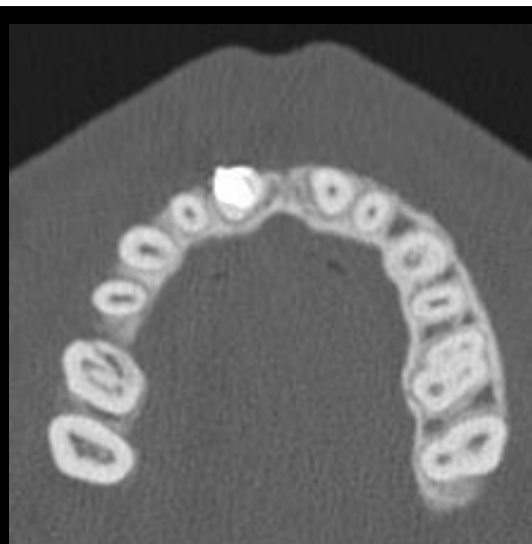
Axial CT Maxilla
